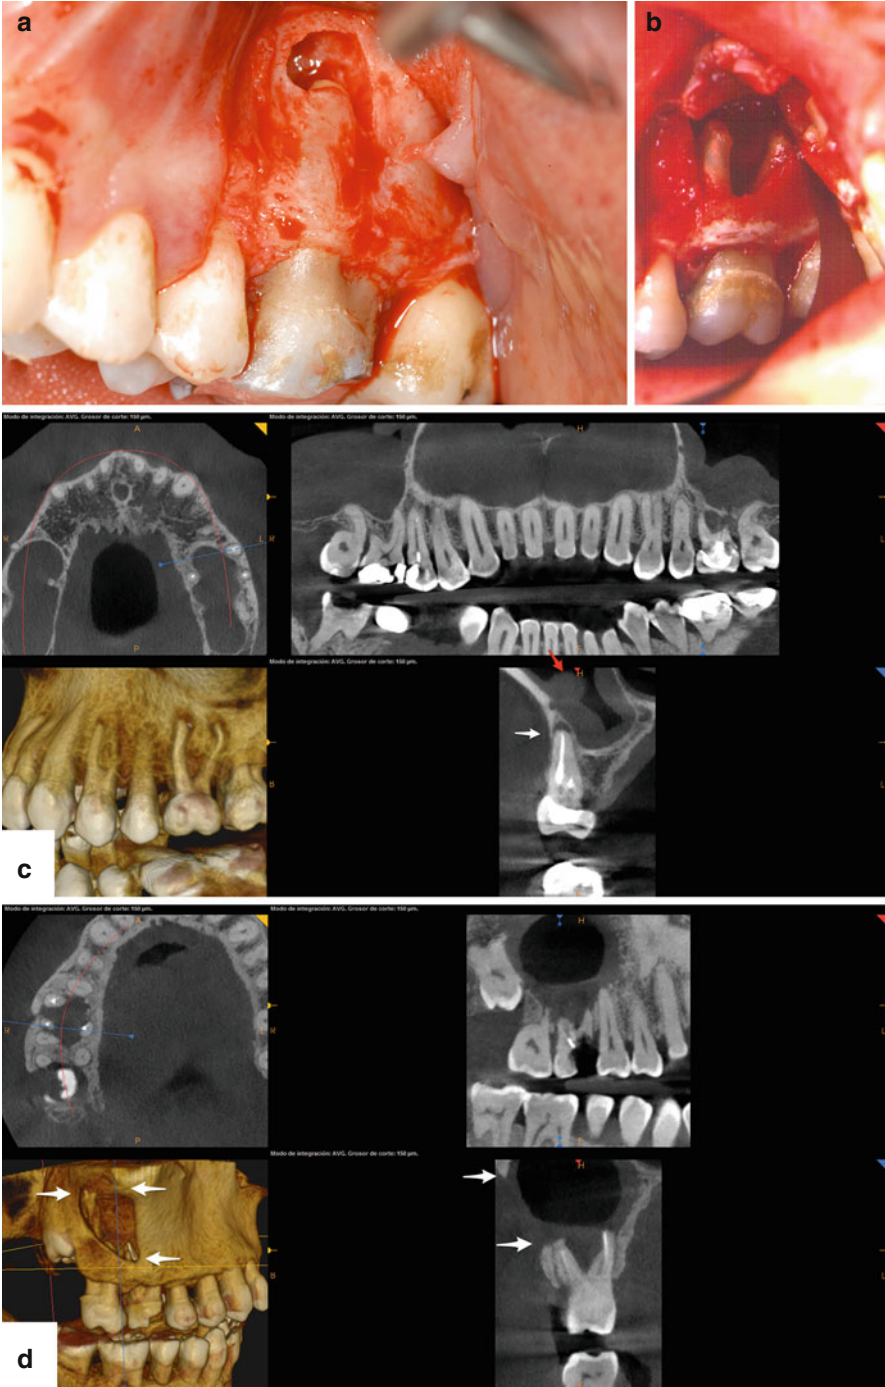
(a) This small periapical and lateroradicular bone defect is far away from the bone crest. (b) This large periapical bone defect affects two roots and the furcation area. (c) Early periapical bone lesion on the mesiobuccal root of this first upper left molar with the cortical plate intact (*white arrow*). However, the sinus membrane is already inflamed (*red arrow*). (d) Right first maxillary molar with a large osseous defect requiring apical surgery. There is a large through-and-through bone defect with total destruction of the buccal and sinus bone cortical plates (*white arrows*) related to the tooth in question (Reprinted from Merino 2009, with permission)
